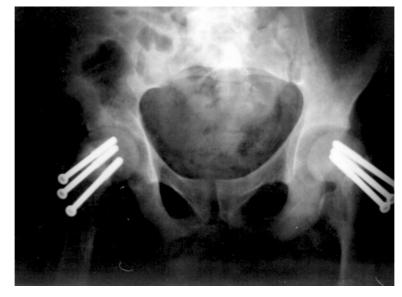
Preoperative and postoperative x-rays of the second patient.
